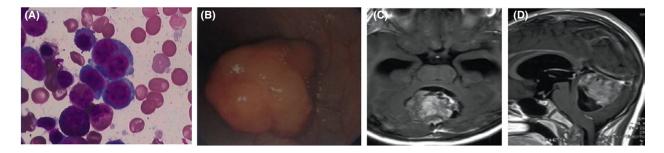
Three primary tumors in the patient. A, Cellular examination of bone marrow smears. B, Adenoma under colonoscopy detection. C&D, Enhanced MR images of cerebellum tumor in coronal and vertical planes
